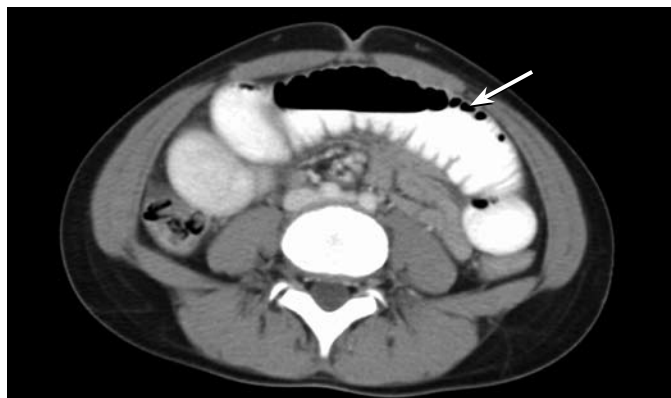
CT abdomen axial image showing small bowel dilation (arrow).
